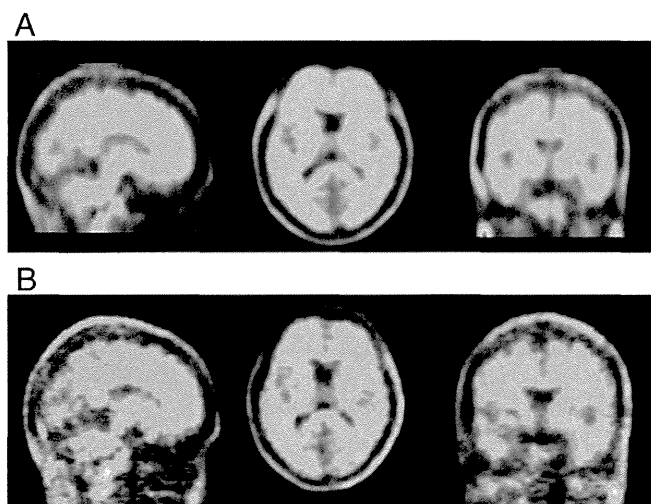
Amyloid PET images 1.5 years (A) and 3 years (B) after brain injury. (A) 1.5 years after brain injury. SUVR=1.27; (B) 3 years after brain injury. SUVR=1.25. SUVR, standard uptake value ratios.
